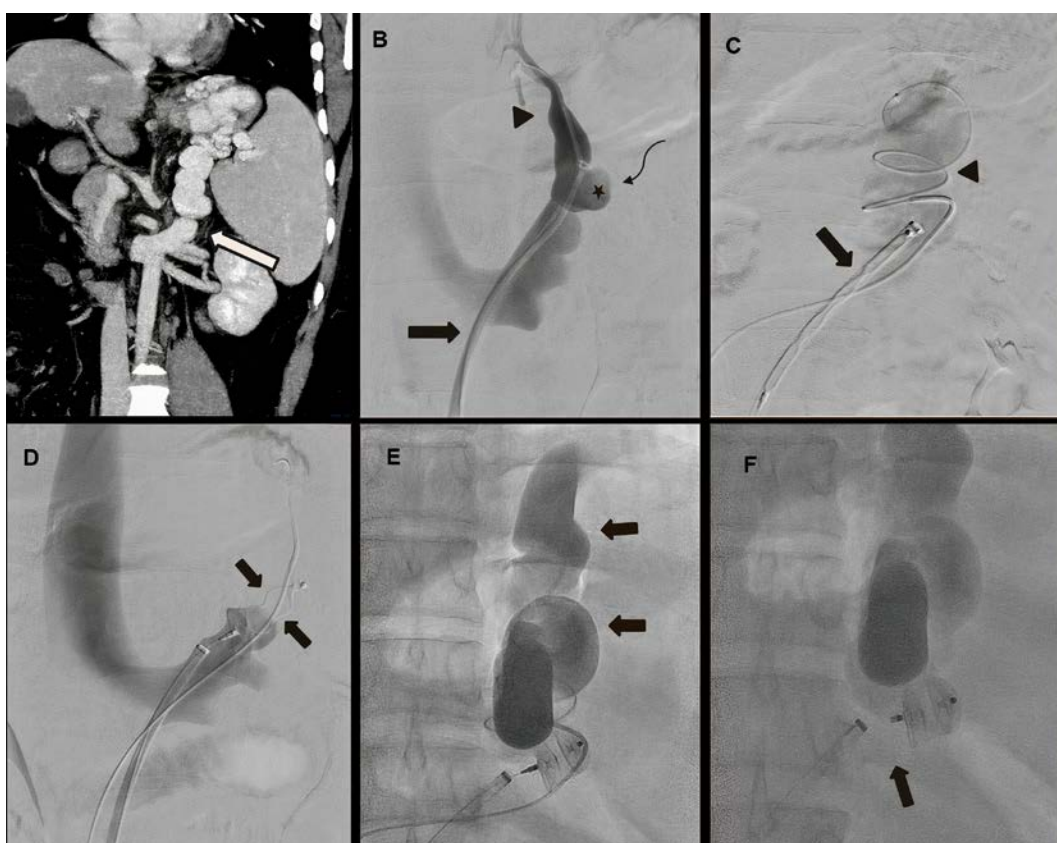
A. Post contrast CT coronal images showing isolated gastric varices with splenomegaly (left-sided portal hypertension)
